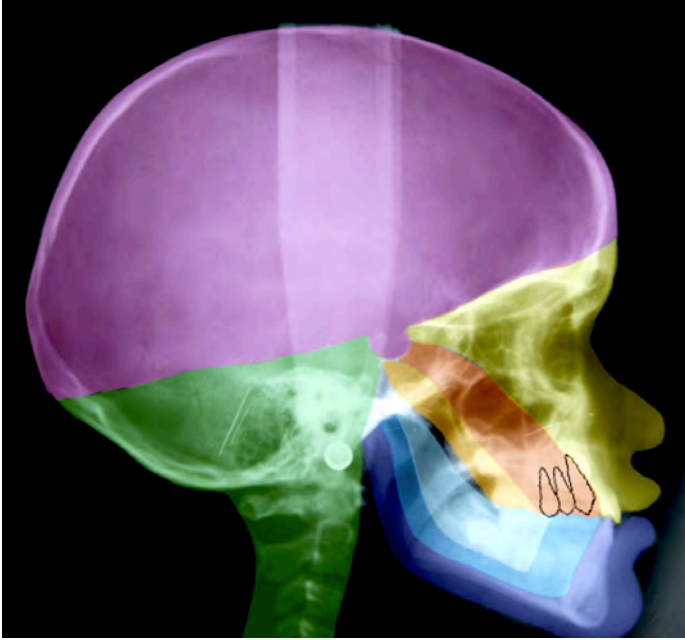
On a profile radiograph of a 9 year-old girl different colored regions are marked indicating the embryological developmental fields defined by Kjær (2009). The maxillary field is the focus of the present study.
